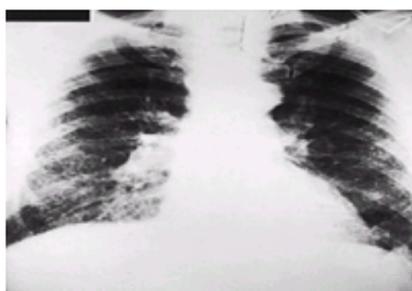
Radiograph of a worker with category 2/3 asbestosis. He had worked for 30 years as an insulator.
